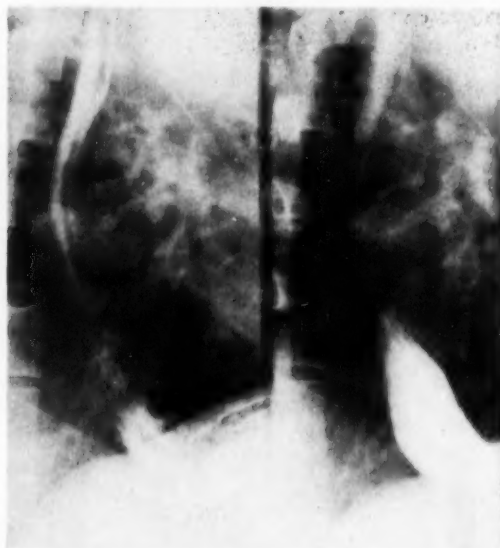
Case 7. Roentgenologically normal esophagus of 59-year old white male with symptoms of heartburn, distention, and acid eructations for several years. Frequent regurgitation of gastric contents in supine and erect positions was noted during fluoroscopic examination.
